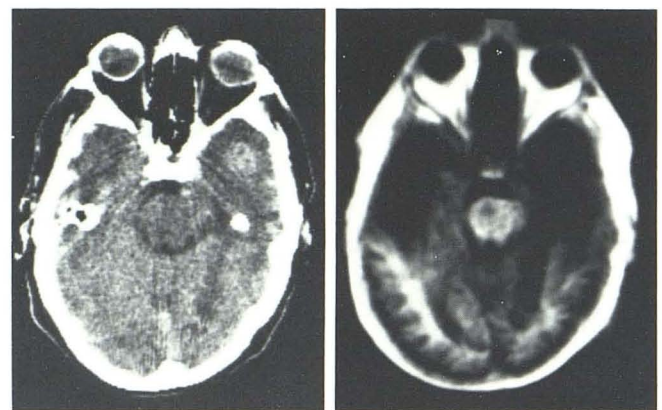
Possible brainstem metastasis. A, Contrast-enhanced CT. B, IR_{1400/400}. Long T₁ region within mesencephalon. Metastases and edema in both temporal lobes.
